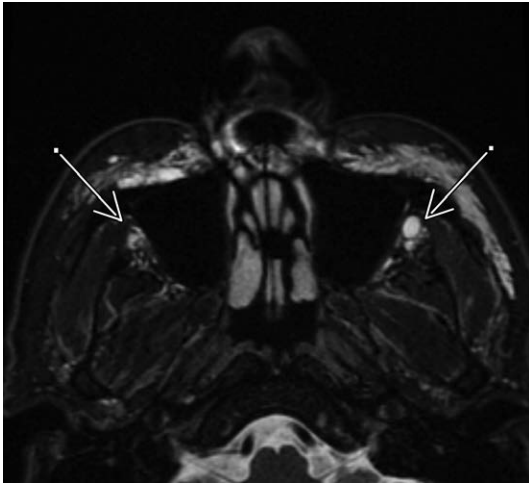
Axial T2-weighted fat saturation 3-T magnetic resonance imaging scan obtained using a GE Pioneer magnetic resonance imaging scanner. *Arrows* indicate the hyaluronic acid signal overlying the lateral wall of the maxillary sinus.
